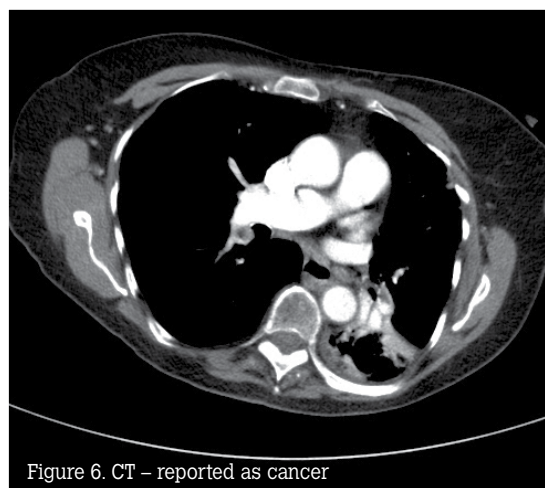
CT – reported as cancer
